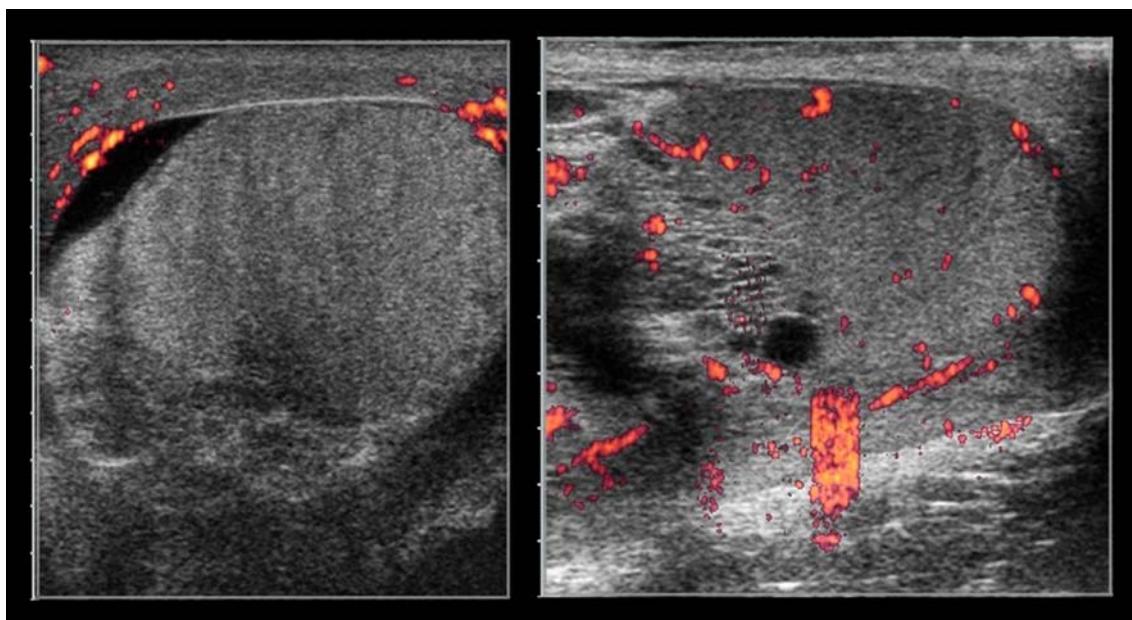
Doppler ultrasound of bilateral testes shows swollen right testis with hypoechoic areas within and reduced arterial signal suggesting testicular torsion with necrosis (*left panel*). This is compared to the left testis which has normal flow (*right panel*)
